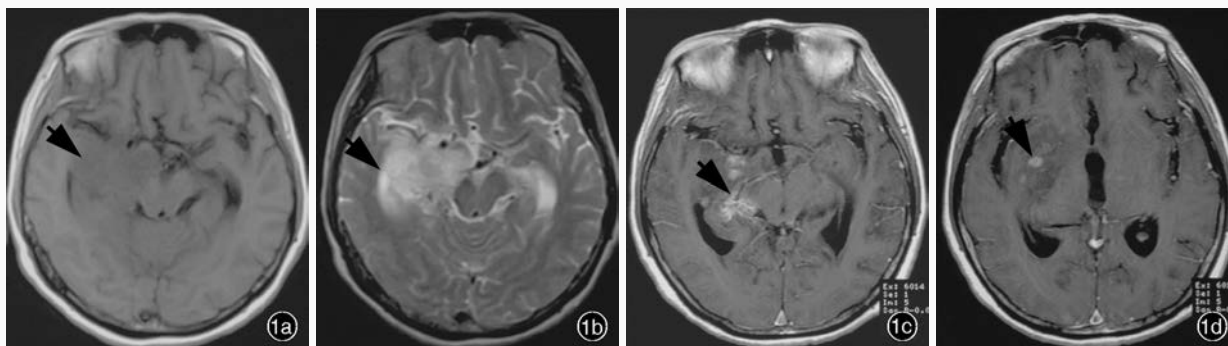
头部 MRI 检查所见 1a 横断面 T₁WI 显示,右侧颞叶内侧和基底节区低信号(箭头所示) 1b 横断面 T₂WI 显示,右侧颞叶内侧和基底节区高信号(箭头所示) 1c 横断面增强 T₁WI 显示,病变内侧散在团块状和斑片状明显强化(箭头所示),中线结构向左侧偏移 1d 横断面增强 T₁WI 显示,右侧基底节区病灶内侧散在团块状和斑片状强化影(箭头所示)
